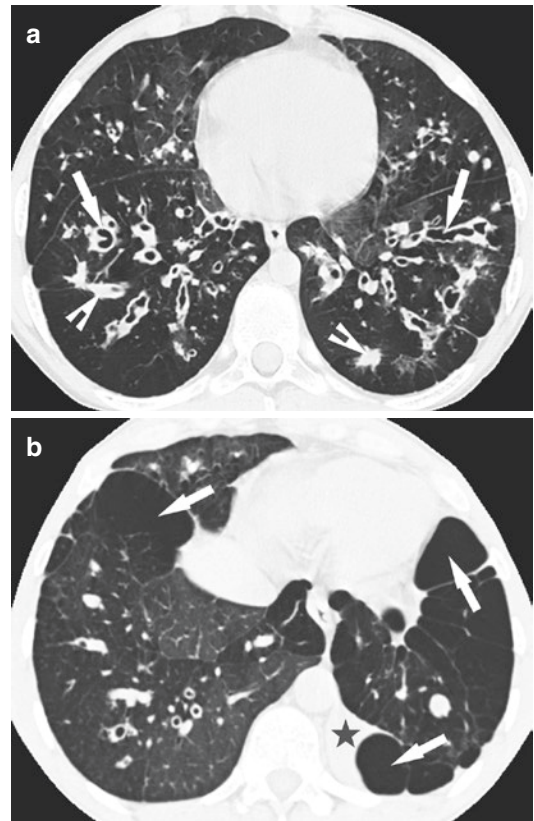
(a) *Cystic fibrosis* (CF) patient showing varicose bronchiectasis with bronchial wall thickening (↗) and mucus plugging (↘) as well as mosaic attenuation on inspiratory CT. (b) Another patient with typical findings of CF including mosaic attenuation, and additional lung emphysema (↗) and atelectatic left lower lobe (★)
